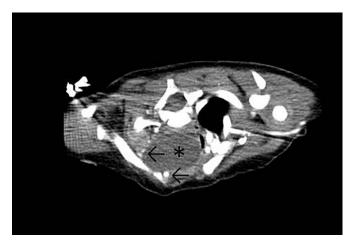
Computed tomography (CT) scan image, in prone position, showing an ovoid cervical lesion (*) next to the esophagus and the neck vessels displaced laterally (arrows).
